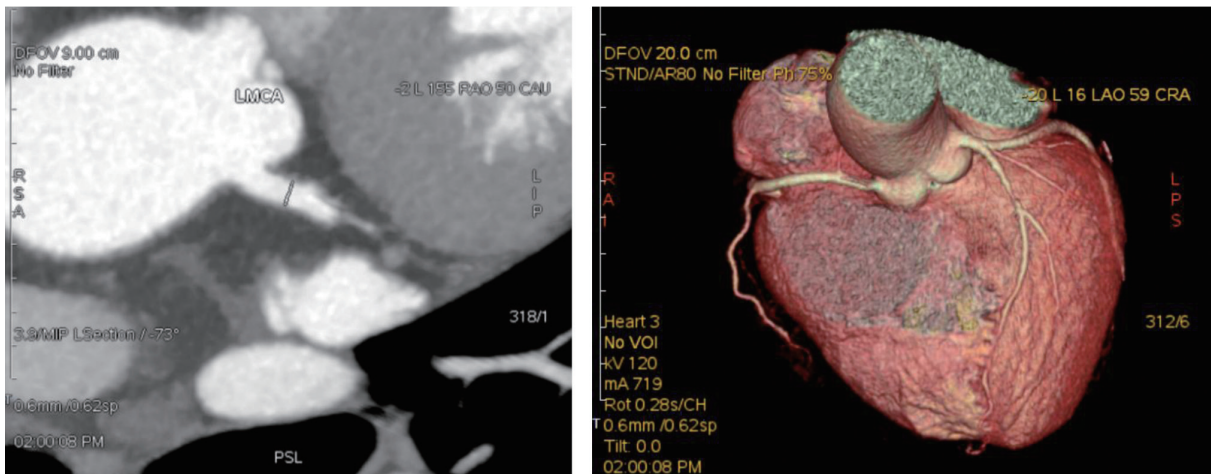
Computed tomography angiography with aorta and left main coronary artery (LMCA) (left) and 3-dimensional rendered image of the coronary arteries (right).
